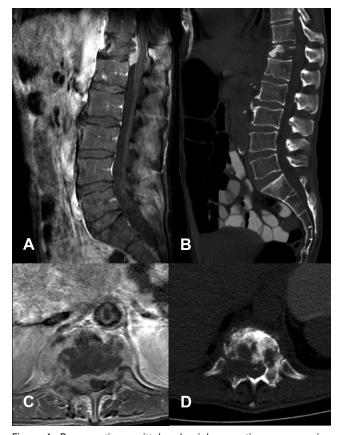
Preoperative sagittal and axial magnetic resonance imaging (A, C) and computed tomography (B, D) showing T12 metastasis with epidural compression.
